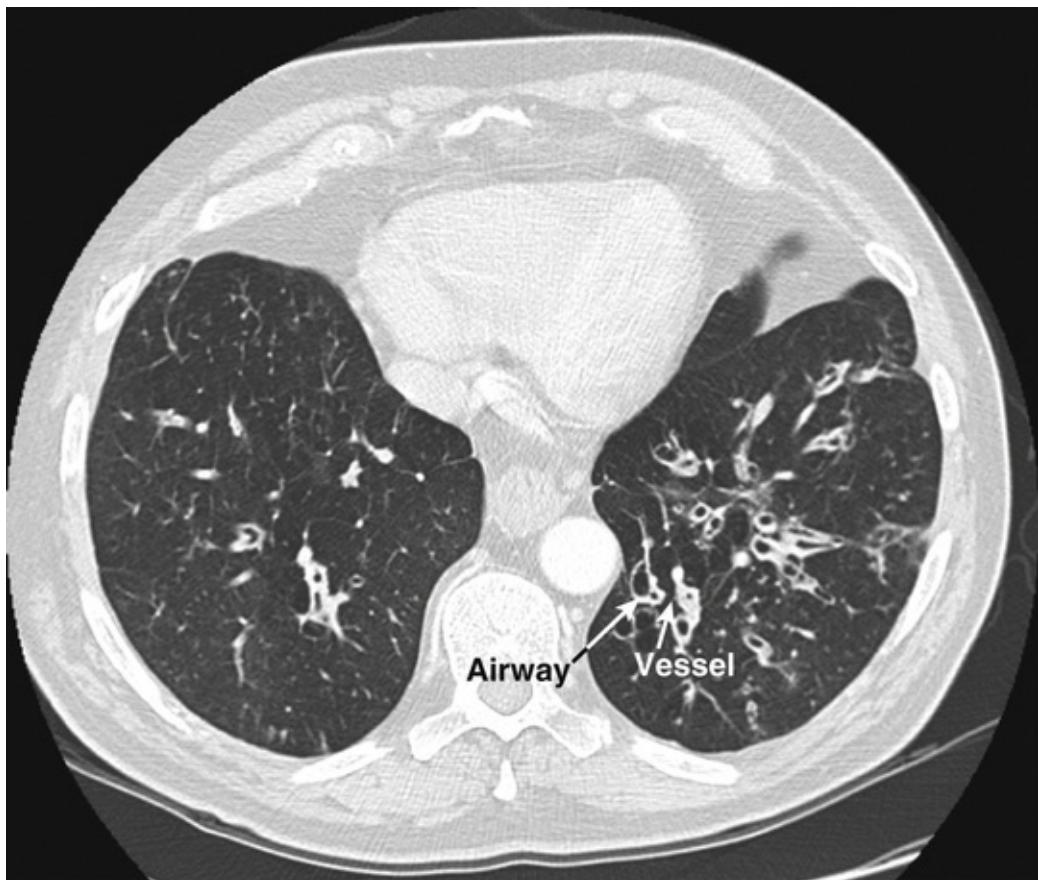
The HRCT scan and bronchiectasis. The airways and vessels are indicated with the arrows.
